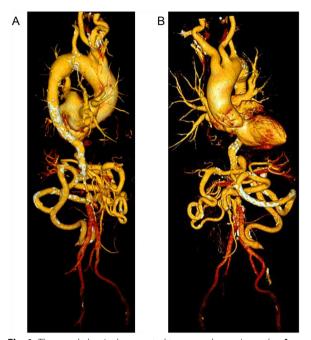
Thoracoabdominal computed tomography angiography; A posterior view showing severe abdominal aortic stenosis (arrow) and dilated visceral arteries; B anteroposterior view highlighting collateral anastomoses
